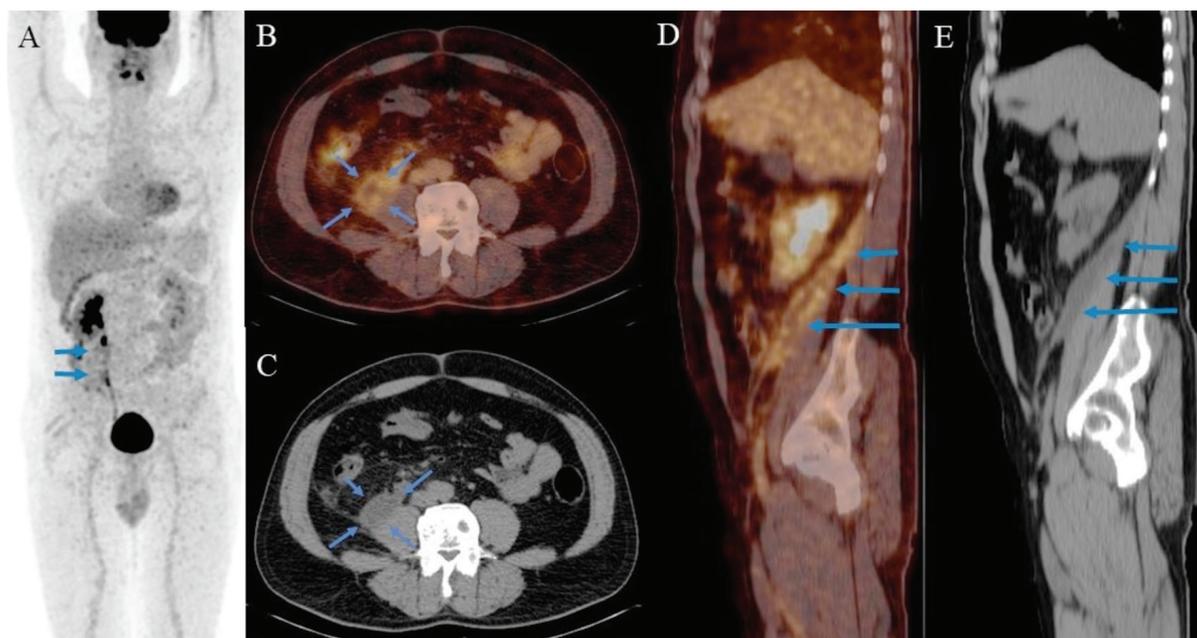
A 47-year-old man with a diagnosis of urothelial carcinoma was referred for primary staging with ¹⁸F-FDG PET/CT scan. The ¹⁸F-FDG PET/CT scanning was performed 15 days after ureteroscopic biopsy. Imaging was performed 60 minutes after I.V. injection of 395 MBq ¹⁸F-FDG, on an integrated 16 slice PET/CT, with scanning from the skull base to the knee. ¹⁸F-FDG PET/CT images [(A) MIP; (B) axial fusion; (C) axial CT; (D) sagittal fusion; (E) sagittal CT) showed tracer accumulation in the fluid collection extending to the pelvis along the retroperitoneal area (SUV_{max}: 4.90, mean density; 1 Hounsfield units), associated with the right ureter, in the right iliopsoas region adjacent to the muscle (A-E blue arrows).
